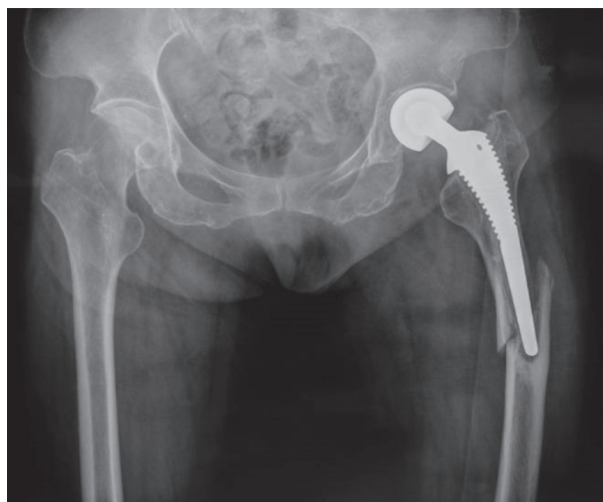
Anteroposterior radiograph of the pelvis showing a B3 type periprosthetic fracture. The stem is loose but there is deficient bone stock in the proximal femur.
